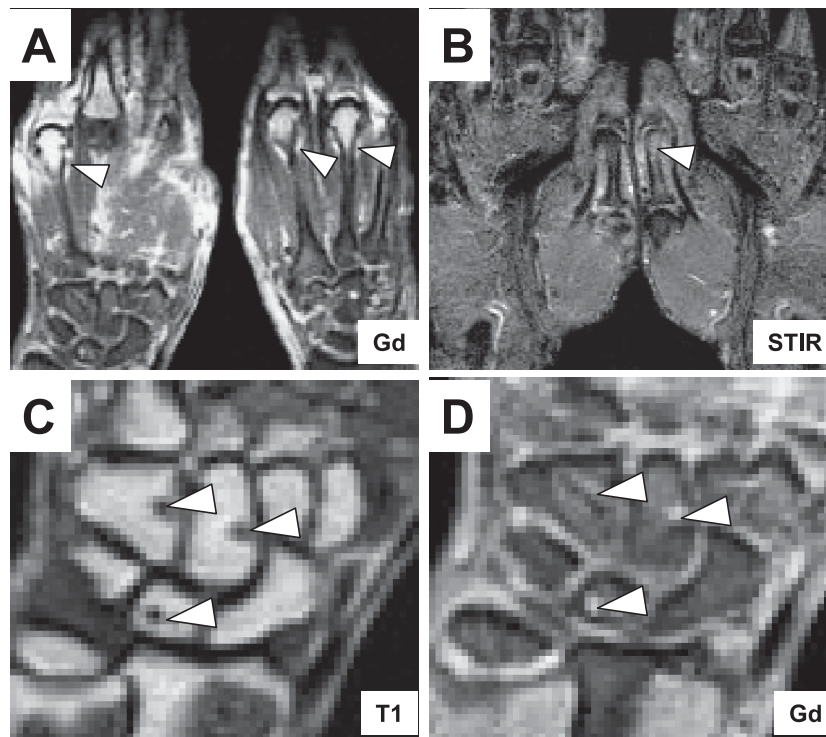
Hand MRI findings. Bilateral synovitis by gadolinium (Gd) enhanced T1-image (A), bone marrow edema in the ossa metacarpi by short TI inversion recovery (STIR)-image (B), and bone erosions in the carpal bones by T1-image (C) and Gd-enhanced T1-image (D), leading to the diagnosis of early-stage RA [7, 8]. Each lesion is indicated by arrowheads.
